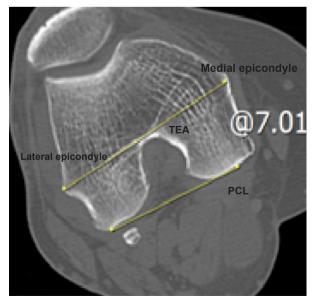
The angle between the epicondylar and posterior condylar axes as measured based on CT images.
